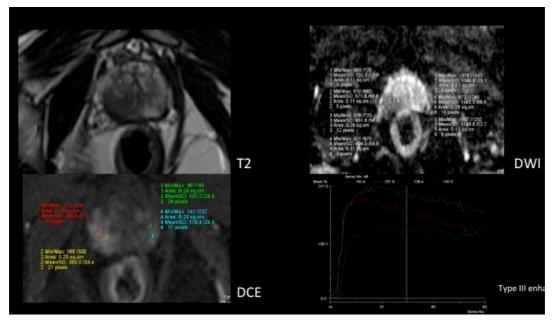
Example of a PIRADS 5 lesion within the right peripheral zone of the prostate on T2 SE, DWI and DCE weighted sequences
